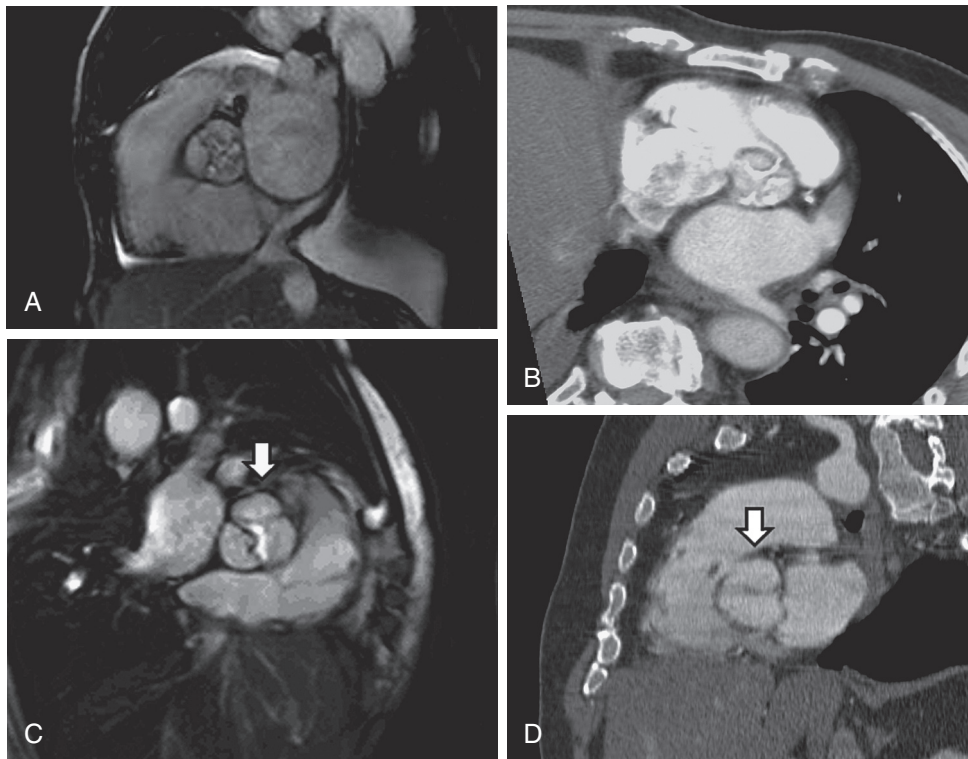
■ Aortic valve disease. Steady-state free-precession cine cardiovascular magnetic resonance (CMR) (A) and cardiovascular computed tomography (CCT) (B) images of a trileaflet, calcified, and stenotic aortic valve in short axis. State free-precession CMR (C) and CCT (D) of a stenotic bicuspid aortic valve.
